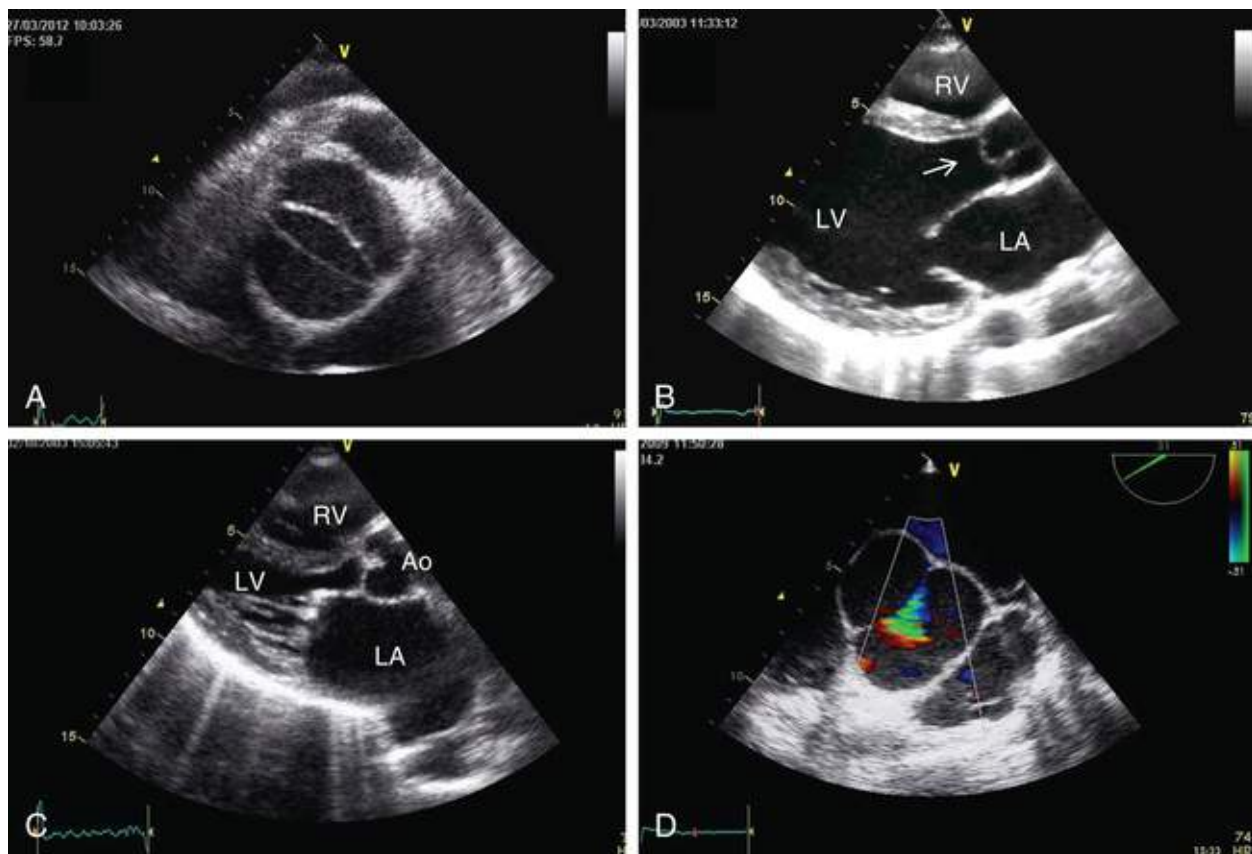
Role of echocardiography in etiologic investigation of aortic regurgitation. A, Transthoracic parasternal short-axis view showing a bicuspid aortic valve. B, Myxomatous aortic valve with a prolapse of the right coronary cusp (*arrow*). C, Rheumatic valvular disease with mitral and aortic involvement. D, Transesophageal image showing a central regurgitant orifice secondary to annuloaortic ectasia. Ao, Aorta; LA, left atrium; LV, left ventricle; RV, right ventricle. (From Tornos P, Evangelista A, Bonow RO. Aortic regurgitation. In Otto CM, Bonow RO, editors. *Valvular Heart Disease: A Companion to Braunwald's Heart Disease*. 4th ed. Philadelphia: Saunders; 2013, pp 163-78.)
